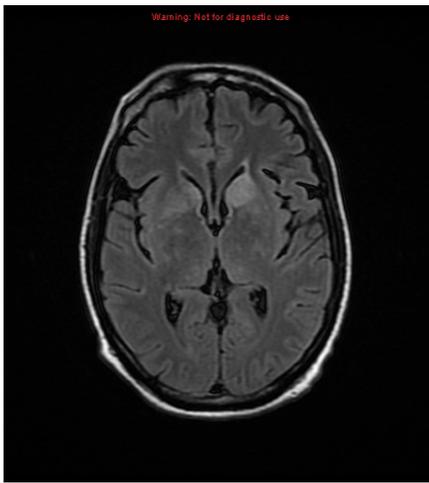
Axial FLAIR image
